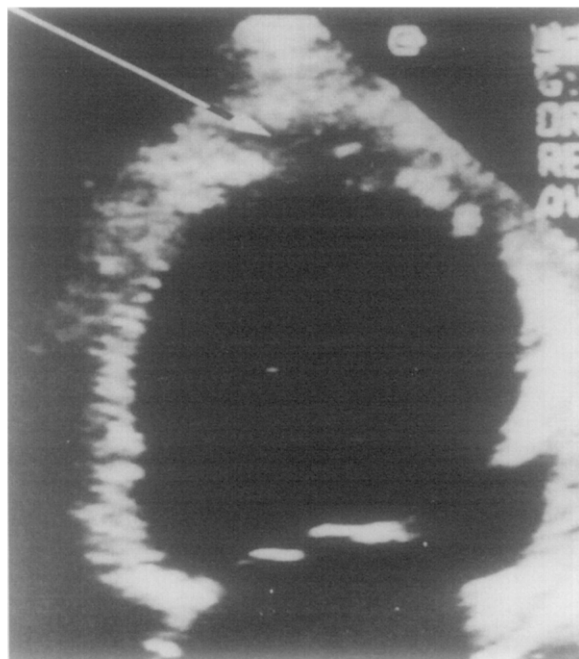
Contrast echocardiogram shows partial-thickness perfusion in patient with apical infarction and patent infarct-related artery from apical four-chamber view. At apex, note evidence of contrast effect in epicardial region with lack of evidence of perfusion in subendocardial area. (From Ragosta M, et al. Microvascular integrity indicates myocellular viability in patients with recent myocardial infarction: new insights using myocardial contrast echocardiography. *Circulation* 1994;89:6;2564.
